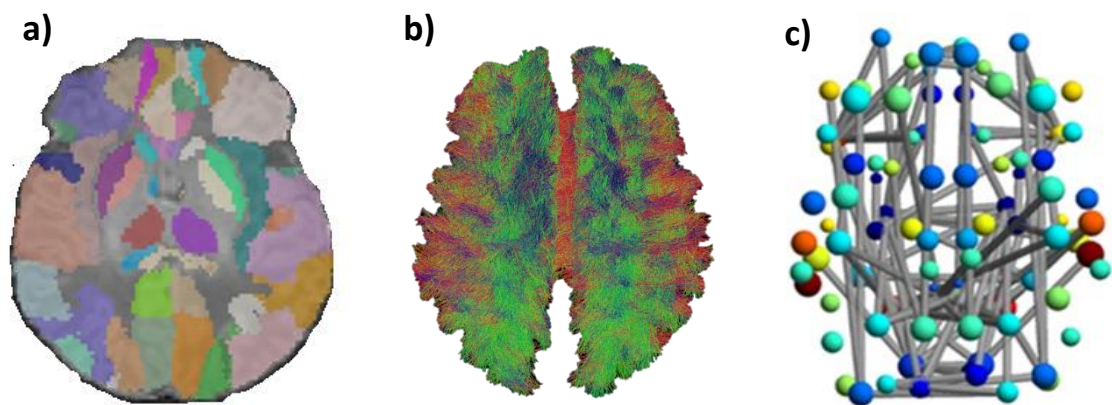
Main steps of the structural connectome framework. From left to right: a) parcellation of the brain in different ROIs; b) tractography of the diffusion MR image; c) merging of both information and creation of a network. Adapted from “Imaging connectivity: MRI and the structural networks of the brain.” by Clayden, J.D. et al. 2013. *Functional Neurology* (168).
